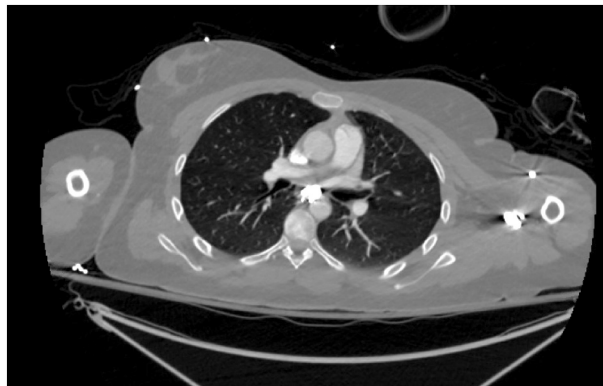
Computed tomography scan of the thorax showing bullet fragment within the posterior mediastinum.
